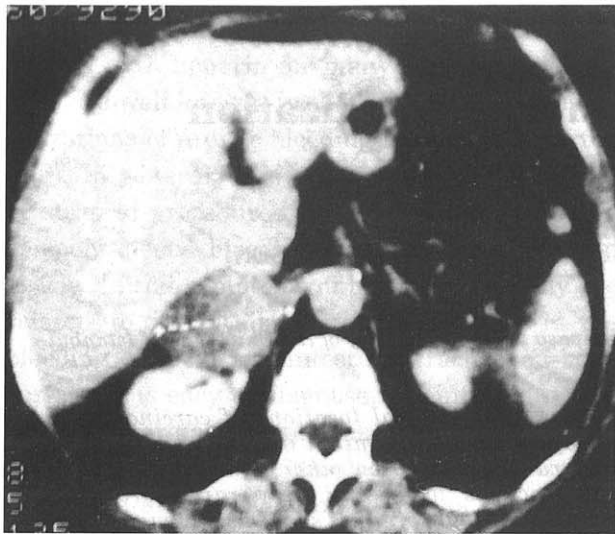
Computed tomographic appearance of tumour.
